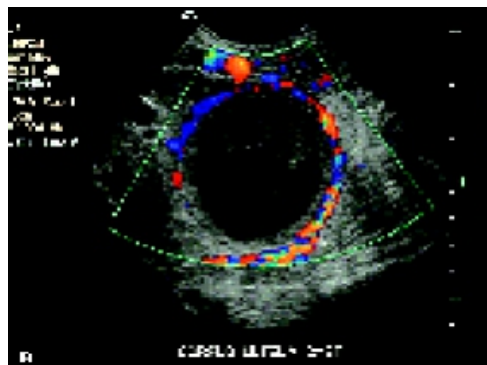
More than 75% blood flow around follicle as seen by Doppler
